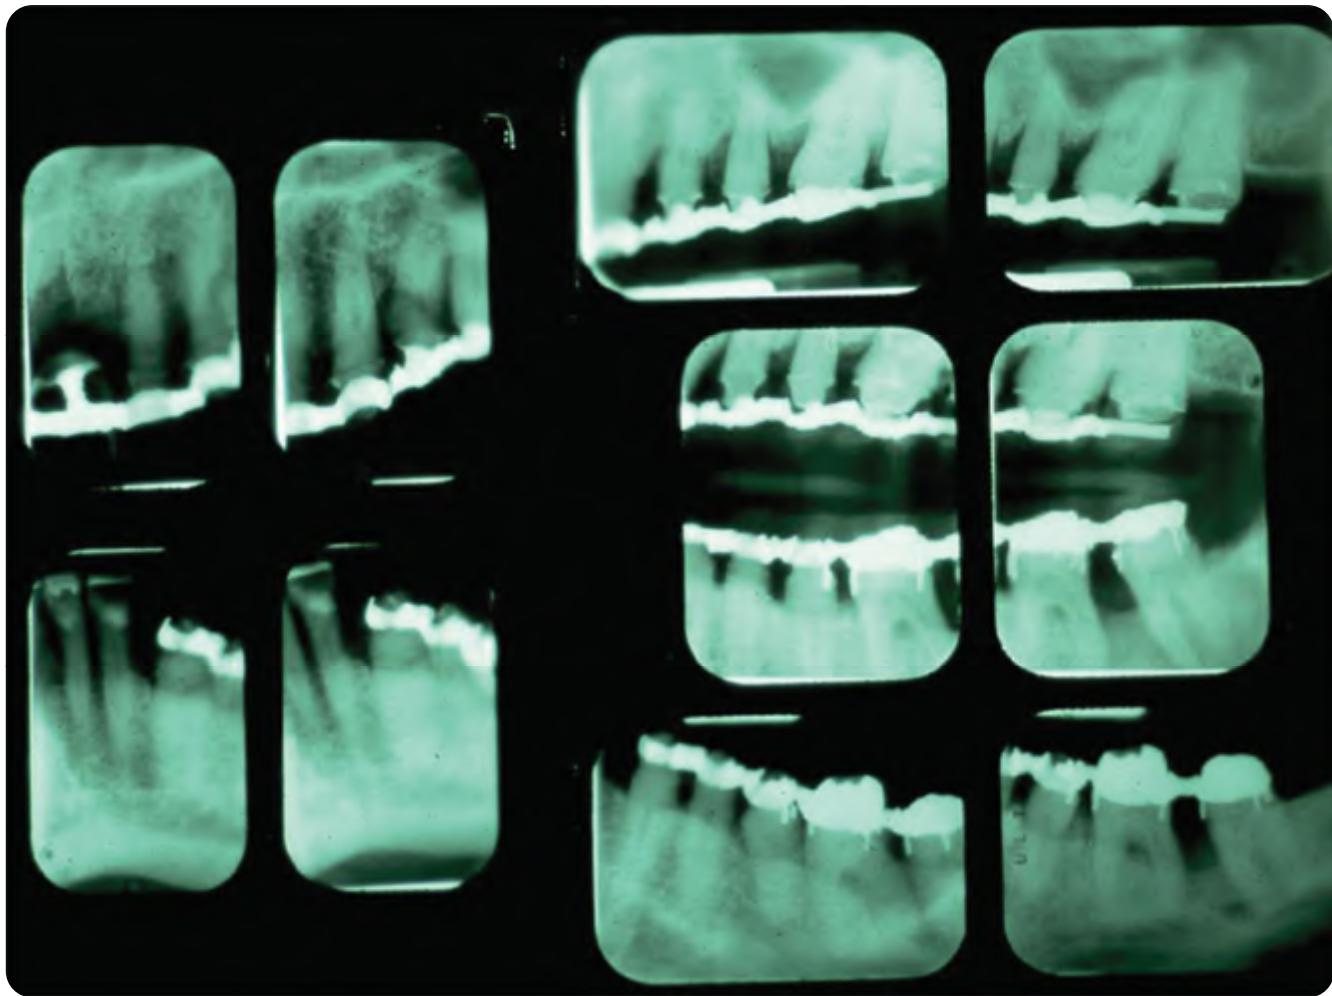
Pretreatment radiographs left side. Note severe bony defects upper and lower left.
